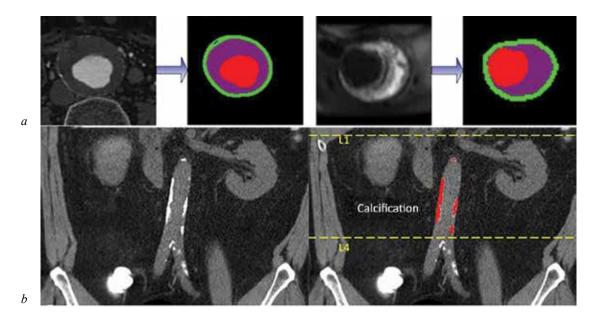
A: The result of CT (left pair) and MR image (right pair) segmentation into 5 classes [33]: red – lumen of the aortic channel; green – aortic wall; purple – thrombus; blue – calcium; black – background (a). Segmentation of aortic calcification using Mask R-CNN automated algorithm: input image (left); the result of the segmentation (right) presented in [34]; L1 and L4 lines mark the area of algorithm application (b)
